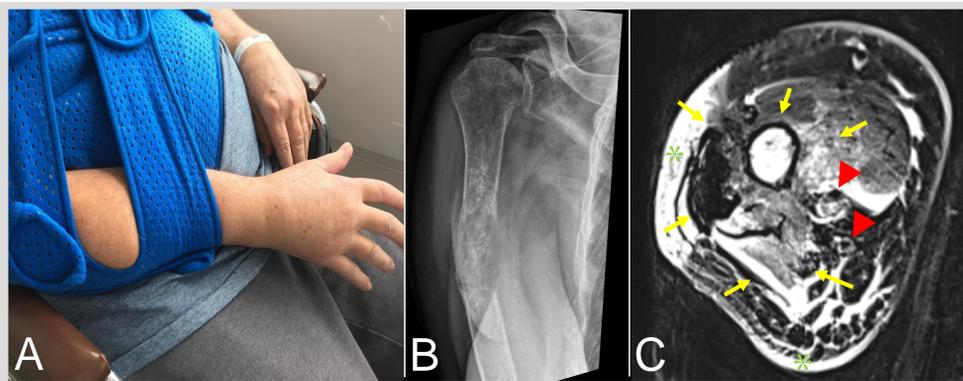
(A) The patient presented in our outpatient clinic with his right arm immobilized in a shoulder brace after diagnosis of (B) his pathological fracture of his upper arm in an secondary Swiss hospital. (C) Axial MRI T2-weighted turbo spin echo (TSE) slice at about the middle third of the right upper arm shows the tumor (arrows) and the surrounding edematous soft tissue (\*). The neuro-vascular structures (arrow heads) are in close proximity of the tumor but not embedded in it.
